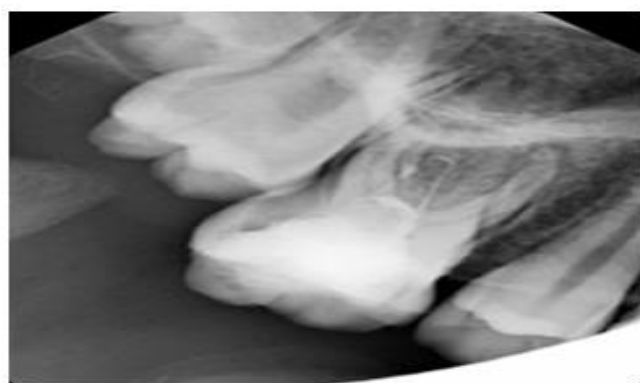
Pre-operative radiograph of tooth #16.
